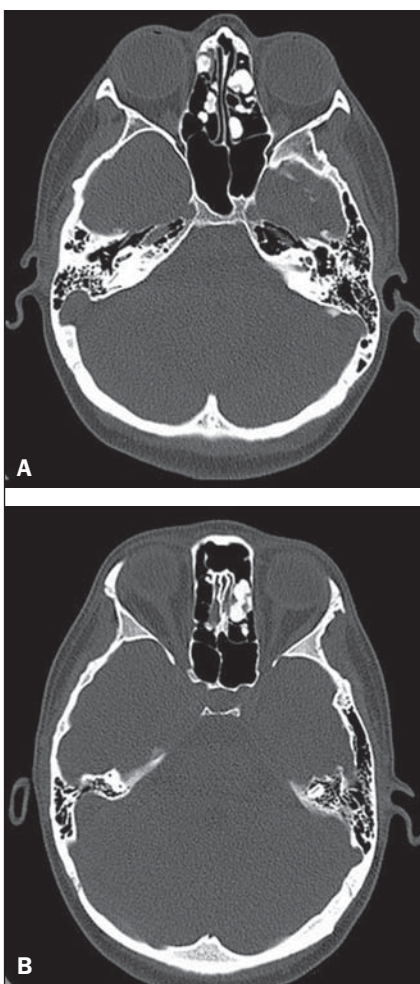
Non-contrast-enhanced CT, bone window.
